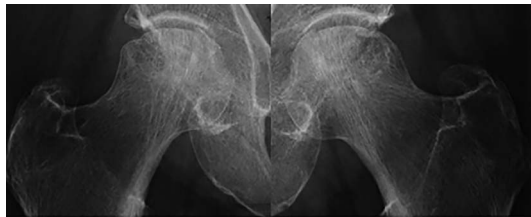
X-rays of both hips with subtle evidence of femoral head collapse bilaterally.
